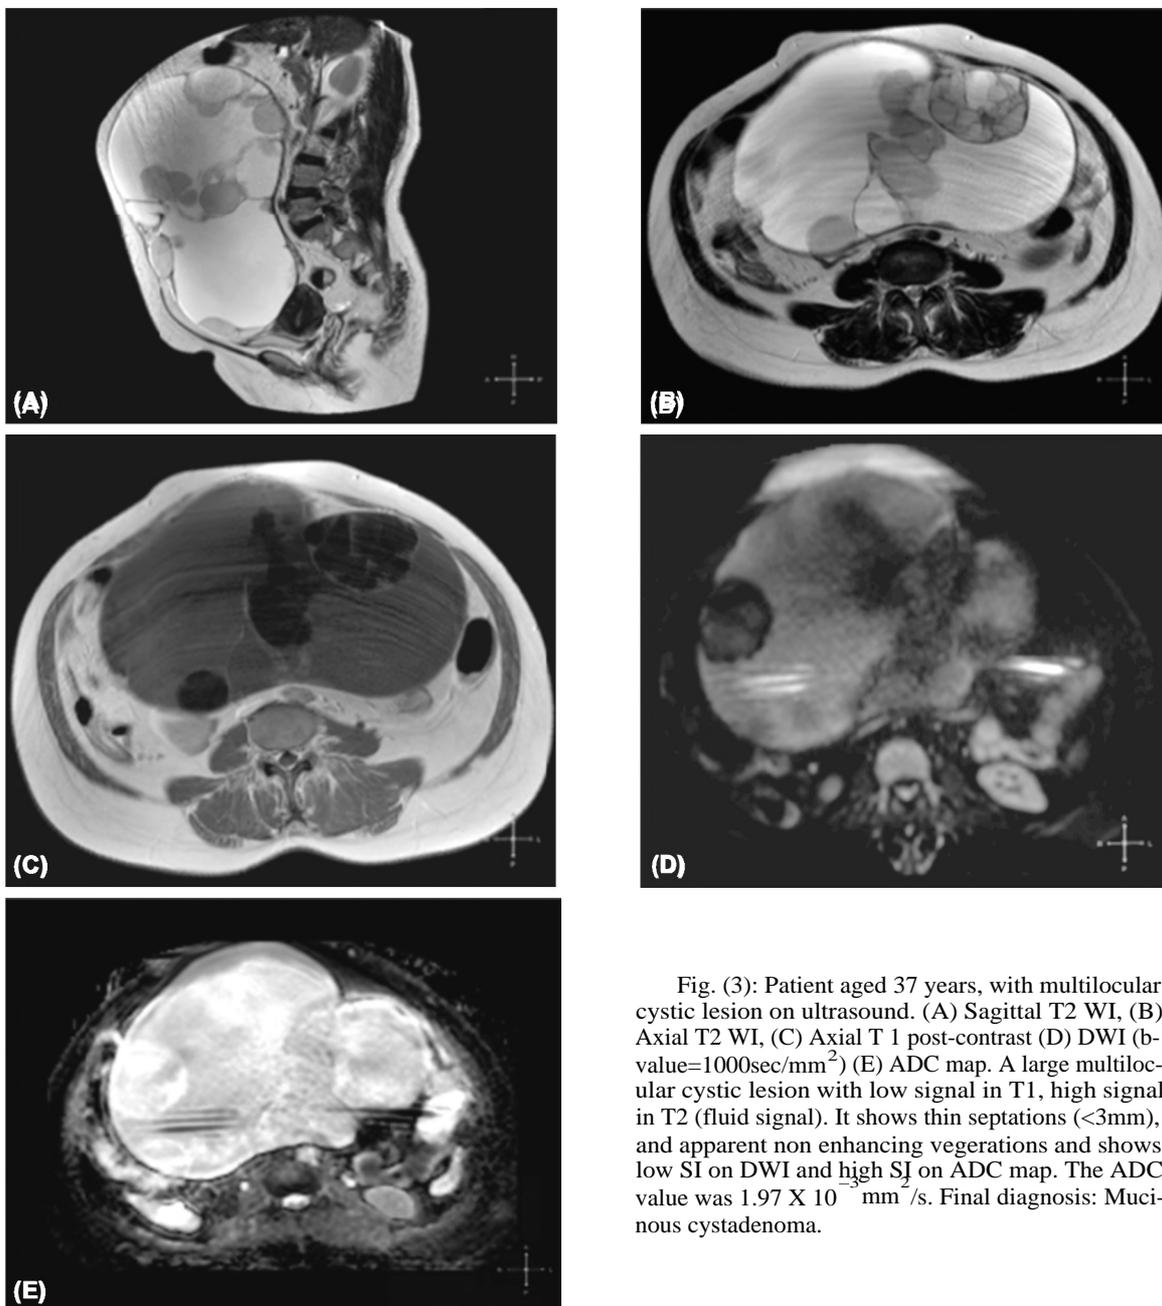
Patient aged 37 years, with multilocular cystic lesion on ultrasound. (A) Sagittal T2 WI, (B) Axial T2 WI, (C) Axial T1 post-contrast (D) DWI (b -value= $1000\text{sec}/\text{mm}^2$) (E) ADC map. A large multilocular cystic lesion with low signal in T1, high signal in T2 (fluid signal). It shows thin septations ($< 3\text{mm}$), and apparent non enhancing vegetations and shows low SI on DWI and high SI on ADC map. The ADC value was $1.97 \times 10^{-3} \text{ mm}^2/\text{s}$. Final diagnosis: Mucinous cystadenoma.
